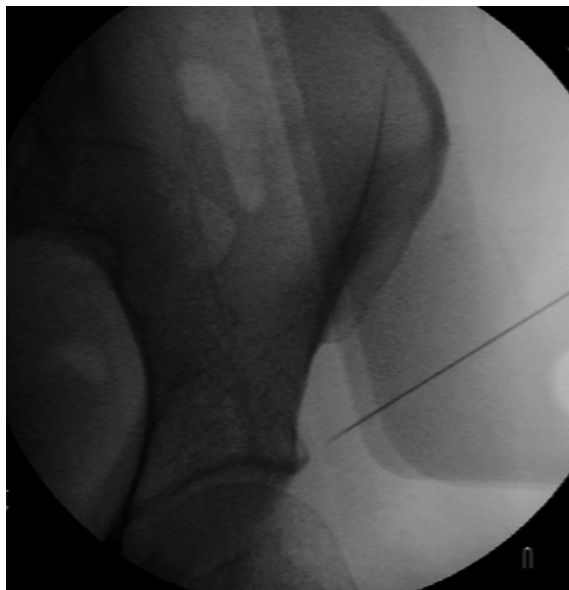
A radiograph showing the entry point of the needle inserted into the LFCN approximately 1 cm medial to the anterior superior iliac spine (ASIS).
